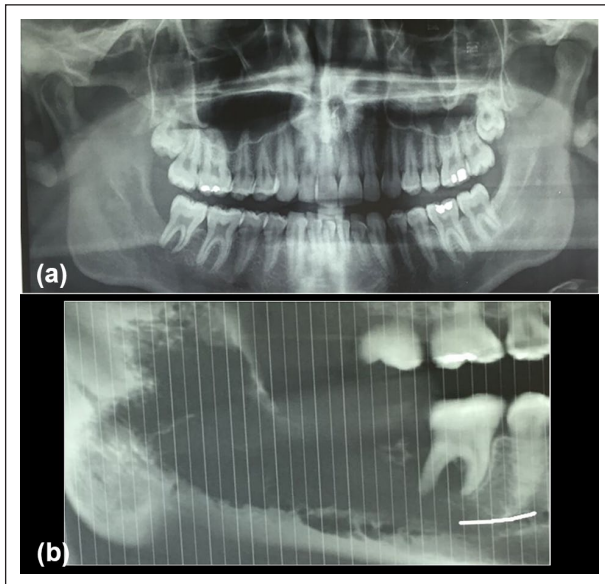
(a) Patient's panoramic radiograph: this radiograph was initially considered non-suggestive of bone destruction in the right mandibular body and ramus. However, a more careful observation would have revealed ill-defined radiolucency of the ascending ramus of the mandible (right side), loss of lamina dura of the second right molar (#47) and loss of the right mandibular canal wall, implying a possible malignancy. (b) CBCT revealed an osteolytic lesion of the right mandibular retromolar area, extending to the inferior alveolar canal and the tooth #46.
